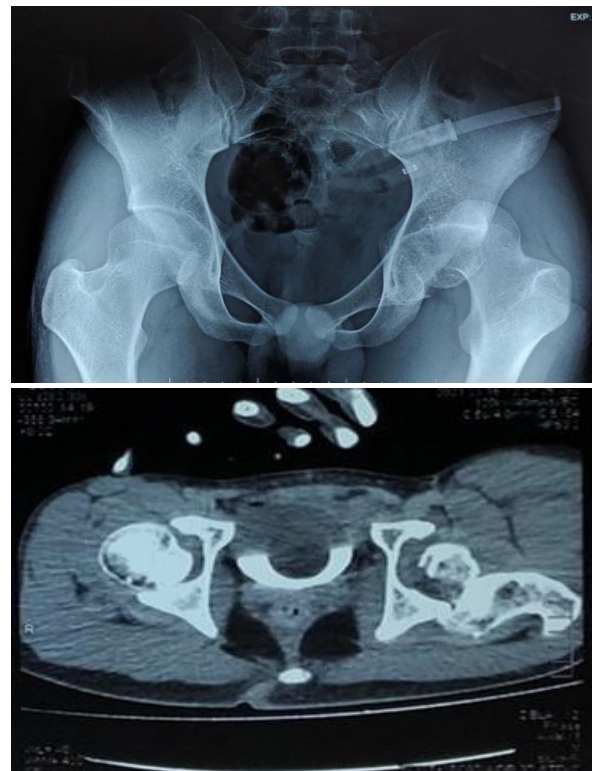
x ray and CT scan of the pelvis showing a femoral head fracture associated with a posterior hip dislocation.
